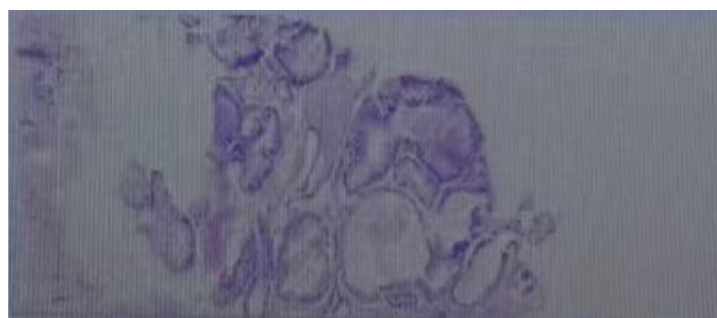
Biopsy pathology of two patients was carried out to confirmed PSMA-positive PCa with Gleason scores: (a) $4 + 3 = 7$ (HE, 100 \times) for patient 1; (b) $3 + 3 = 6$ (HE, 100 \times) for patient 2
